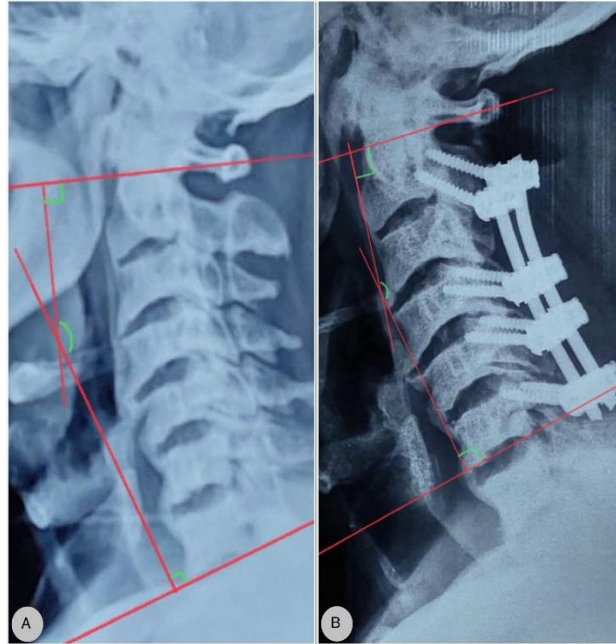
(A and B): Cobb's angle calculation in preoperative and postoperative lateral cervical radiograph: Horizontal line is drawn along superior end plate of C2 and inferior end plate of C7 vertebrae and then angle made between perpendicular lines to the above two horizontal lines is calculated to be as Cobb's angle. Highlighted area inside red circle shows the relation between CSF and spinal cord.
